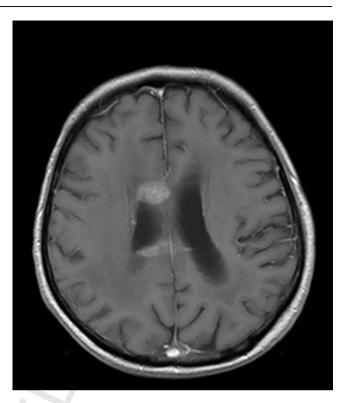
T1-weighted contrast-enhanced MR imaging presents contrast enhancement of the tissue infiltrating the right lateral ventricle wall before treatment.
